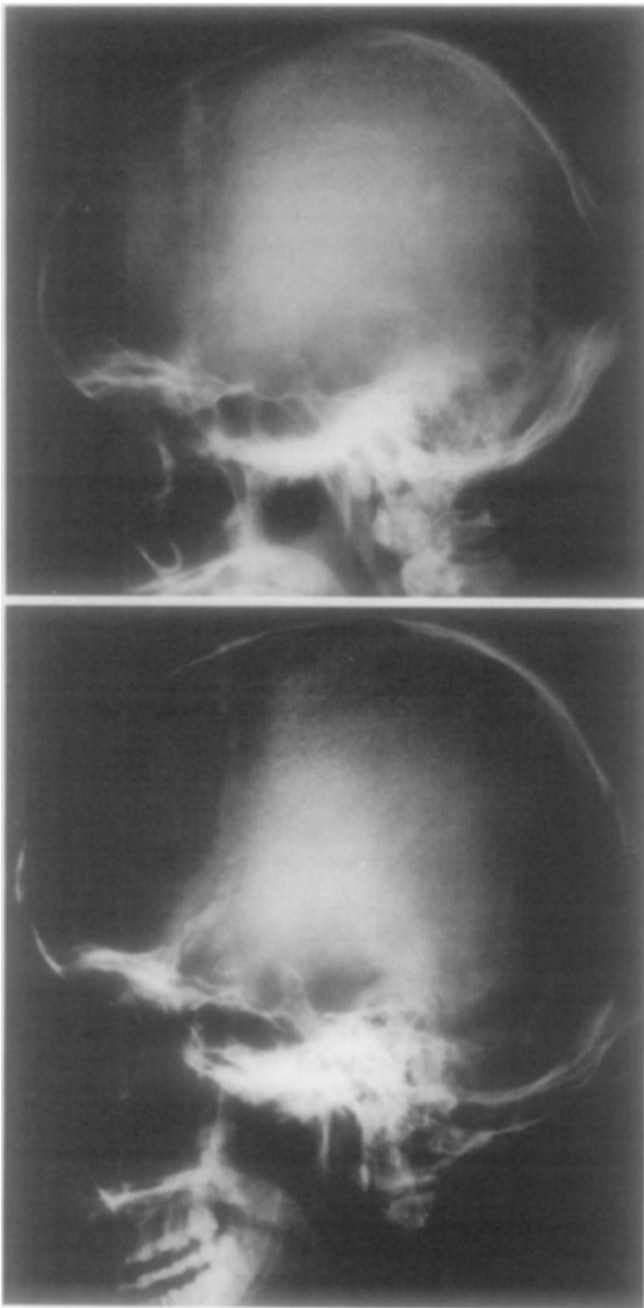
Skull radiographs. A, December 20, 1991, normal skull; B, May 1, 1992, lytic lesion of the frontal bone.
